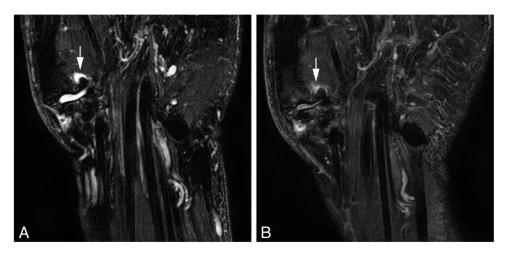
Coronal fat saturated T2-weighted fast spin-echo magnetic resonance imaging from a study participant showing an increase in synovitis in the first carpometacarpal joint (arrows) at a two-year follow-up visit (A) compared to baseline (B).
